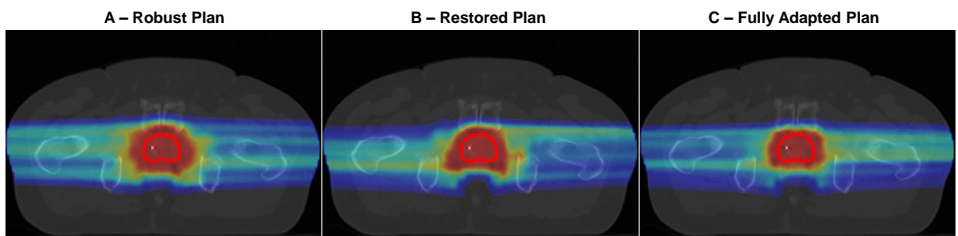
An example of the dose distributions obtained using the different strategies for one repeat CT scan. The red contour indicates the daily CTV_{High} .
